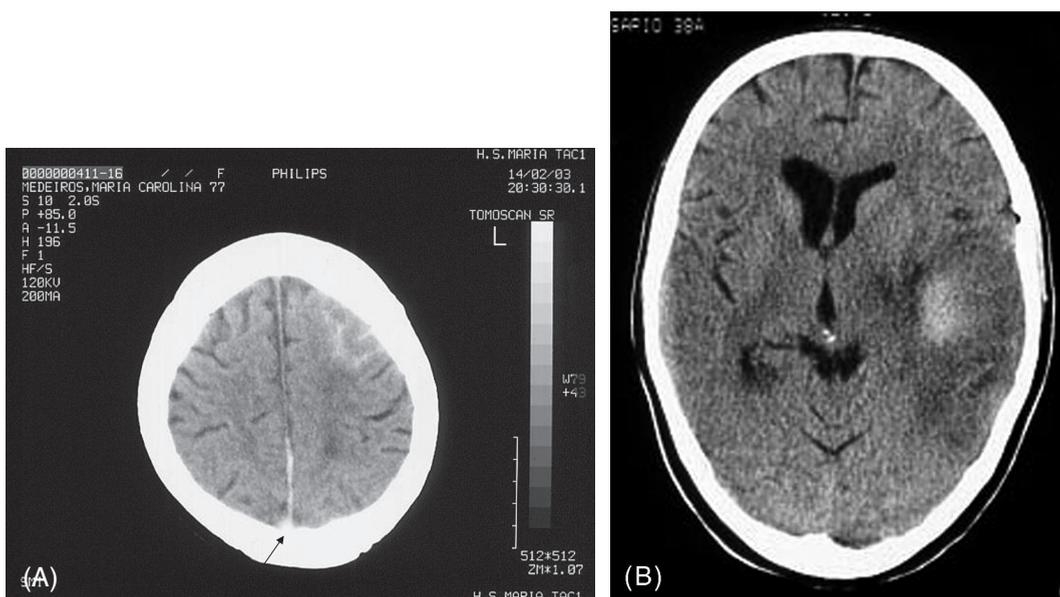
CT imaging of sinus thrombosis. (A) Subarachnoid hemorrhagic densities and the dense triangle sign (arrow) in a patient with thrombosis of the superior sagittal sinus. (B) Left hemorrhagic infarct in lateral sinus thrombosis.
